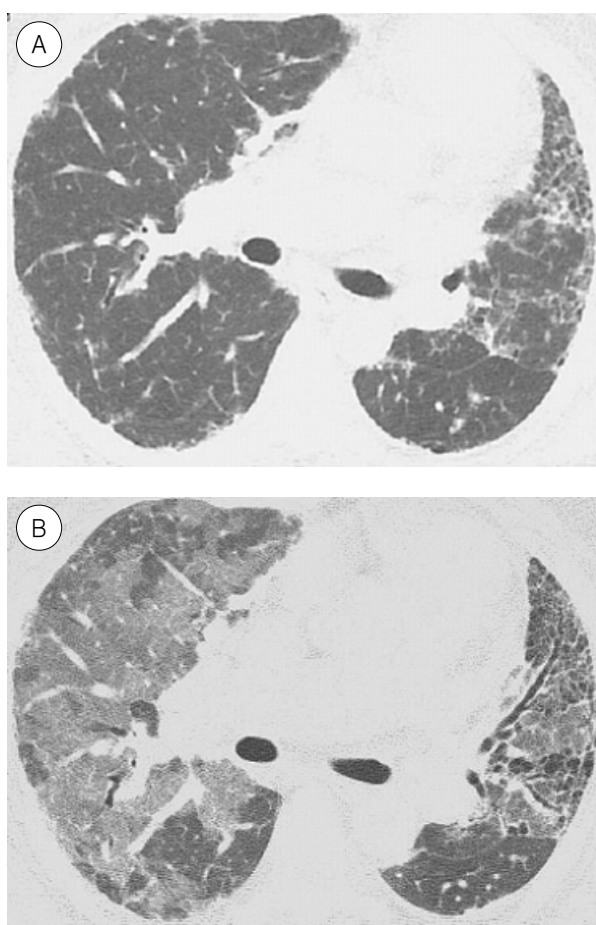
Acute exacerbation of IPF in a 63 year-old man. (A) Initial HRCT scan obtained at level of bronchus intermedius shows subpleural predominant reticular opacities, honeycombing and subtle areas of ground glass opacity, typical of IPF. (B) After 7 months, the follow up CT scan obtained at similar level shows extensive multifocal areas of ground glass opacity, superimposed on a background of IPF.
